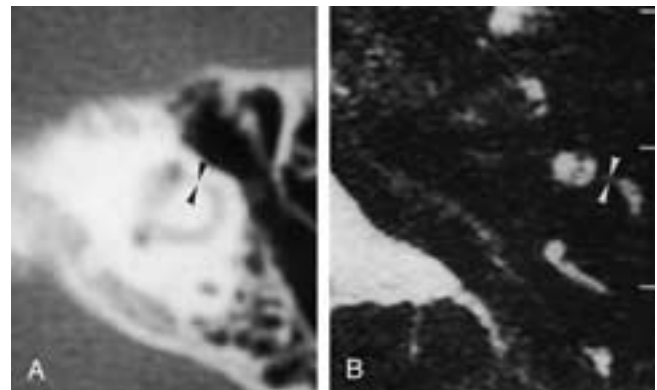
Stenosis of the ampulla of the lateral semicircular duct in a patient with the branchio-oto-renal syndrome. A, Axial CT image through the left lateral semicircular canal. The lateral semicircular canal is narrowed at the site where the ampulla normally is found (black arrowheads). B, Corresponding axial T2-weighted gradient-echo image through the left lateral semicircular duct. The fluid-filled ampulla of the lateral semicircular duct is stenotic (white arrowheads).
